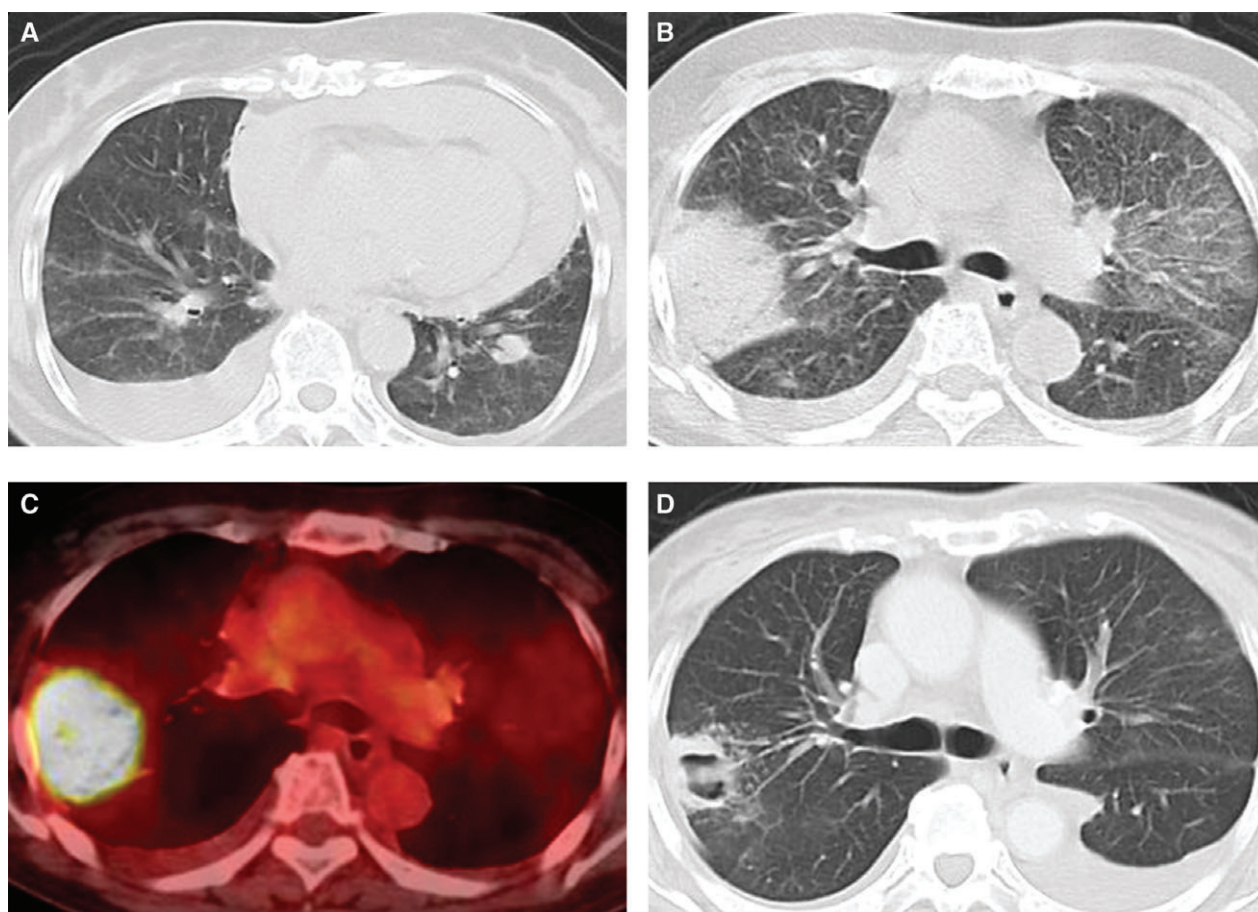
(A) Thoracic computed tomography (CT) showing pericardial fluid, tiny left effusion as well as right-sided fluid, with a 1.5 cm × 1.2 cm nodule in the left lower lobe. (B) Thoracic CT 2 weeks after the first CT, showing a new mass lesion in the right upper lobe and widespread ground-glass opacification in both lung fields that had rapidly increased. (C) Positron emission tomography-CT 2 weeks after the second thoracic CT, showing 18F-fluorodeoxyglucose avid mass in the right upper lobe. (D) Radiological response was noted post initiation of treatment.
